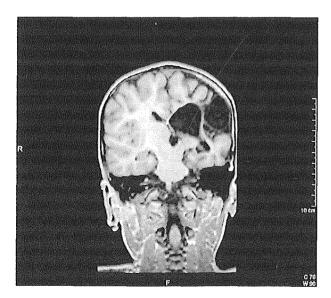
MRI (coronal view) at the age of 5 years and 2 months. Large left middle cerebral artery infarct. The left thalamus is atrophic and the right hemisphere is uninvolved.
